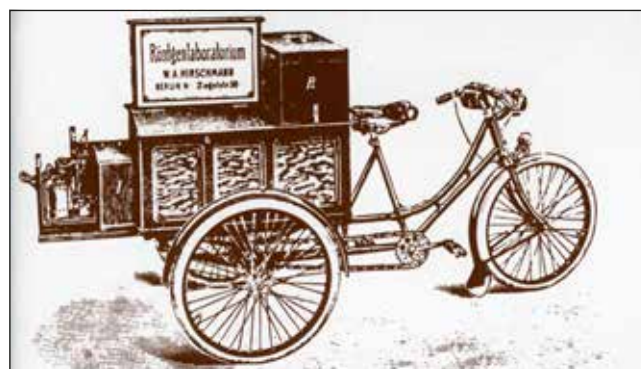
Portable X-ray machine – 19th Century
